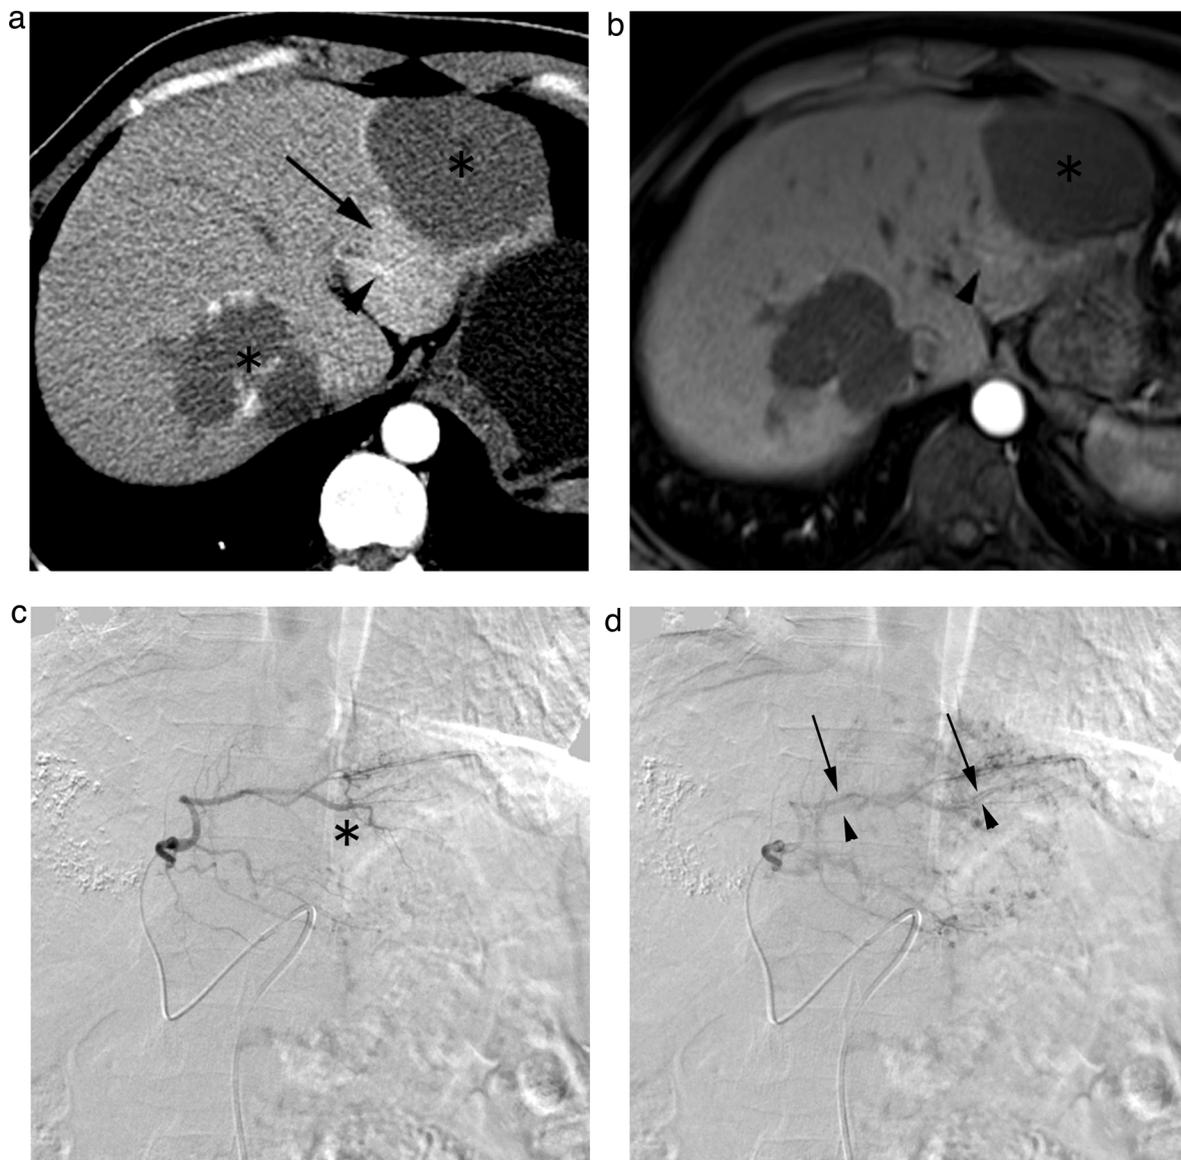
Peripheral APS associated with a HH. (a,b) Contrast-enhanced axial CT (a) and MR T1W image (b) obtained during hepatic arterial phase show two HH lesions (asterisk) in segment II and VII. Note that the early irregularly shaped parenchymal enhancement (arrow) adjacent to the HH in segment II with internal branching structure (arrowhead), which is consistent with the peripheral APS. (c) Selective left hepatic arteriogram obtained during the early arterial phase confirms the hypervascular tumor (asterisk). (d) Arteriogram obtained during the late arterial phase shows early filling of small portal branches (arrowhead), parallel to the accompanying hepatic artery (arrow), which is termed as parallel track sign.
